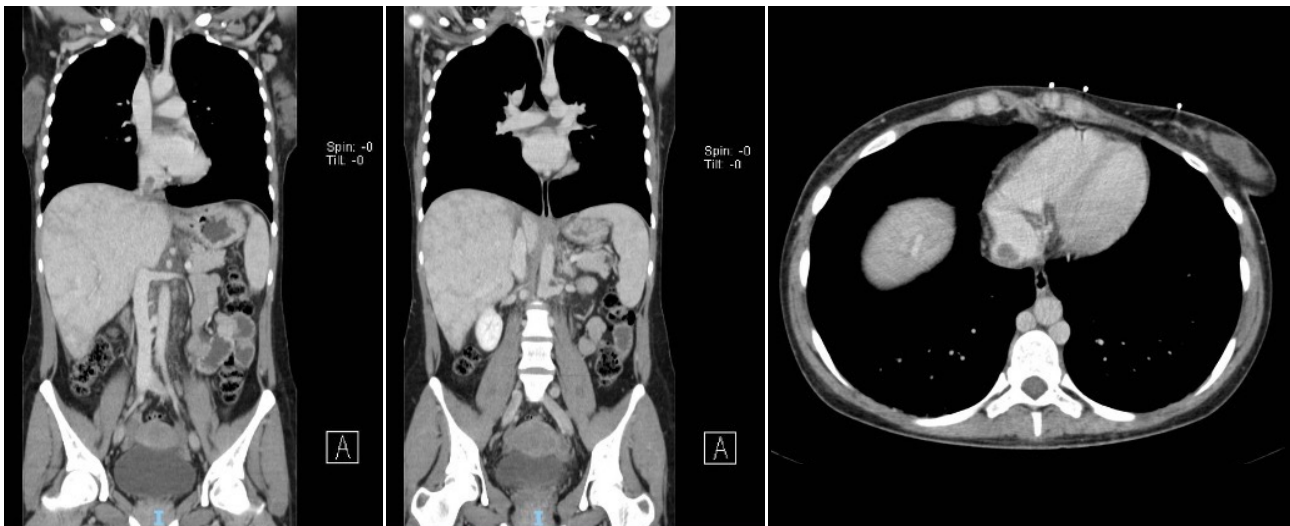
Computed tomography scan with extensive thrombotic formation from the intrahepatic inferior vena cava to the right atrium.
